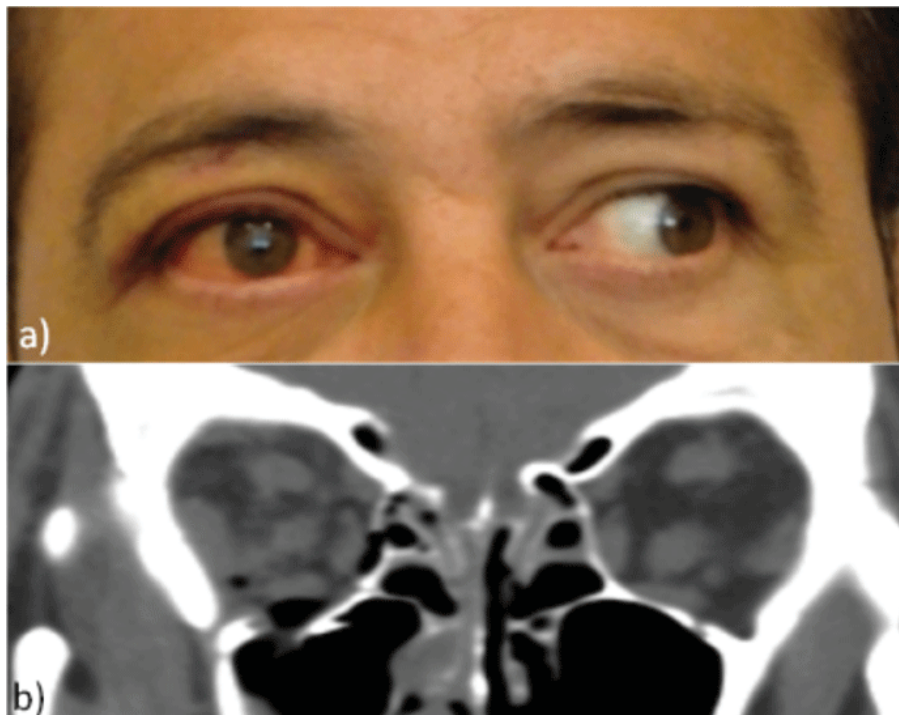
CT scan (a) of a patient with inferomedial BOF of right orbit and paresis of right medial rectus muscle and limitation to adduct the right eye remaining 7 days after the injury (b). This patient was considered to have impingement of right medial rectus muscle.
